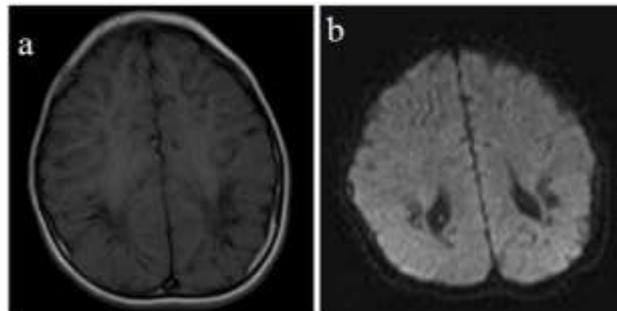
Axial MR T2WI (a) and DWI (b) images at the level of lateral ventricles show areas of altered signal intensity involving the cerebral white matter with relative sparing of the periventricular white matter and deep nuclei appearing diffusely hyperintense on T2WI images with corresponding restriction on DWI. This is suggestive of acute infarct with the white brain pattern of injury.
